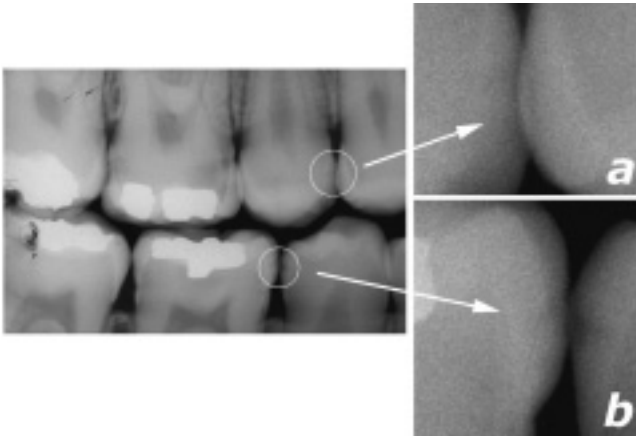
A bitewing radiograph. How sure can a clinician be of a diagnosis of (a) a sound interproximal surface between the premolars and (b) caries interproximally between the second premolar and the first molar? Does this radiographic view alone justify a clinical decision to restore these teeth? Research suggests that the clinician can be very certain of the lack of disease in (a) (specificity of this diagnostic procedure is 97%) but much less certain of the presence of disease in (b) (sensitivity of this procedure is only 54%).
